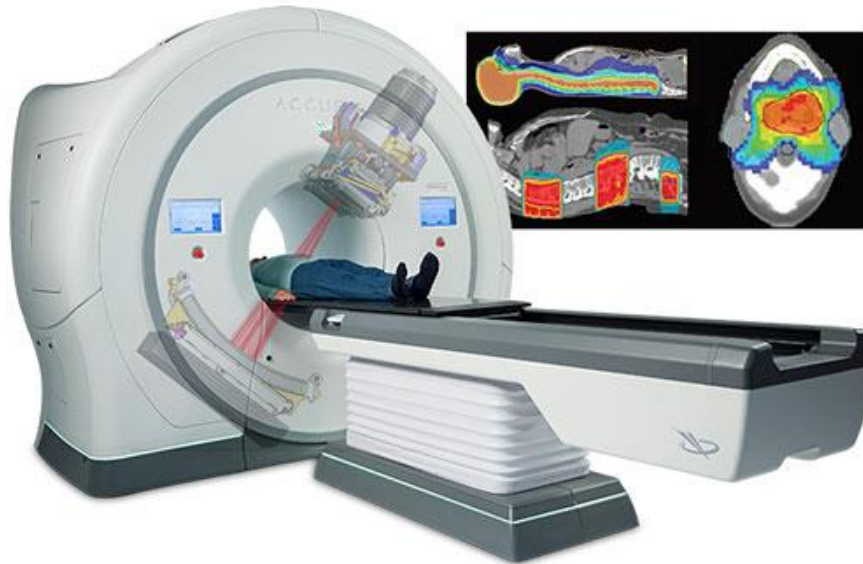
View of the Tomotherapy machine: with its rotating tube and moving couch, its aspect is similar to that of a CT-scanner, but the accelerator delivers a high energy 6 MV beam (instead of 120 kV for the CT). Some typical treatment isodoses are shown in the superior right corner (Accuray, Sunnyvale CA, <https://www accuray.com/tomotherapy/>).
